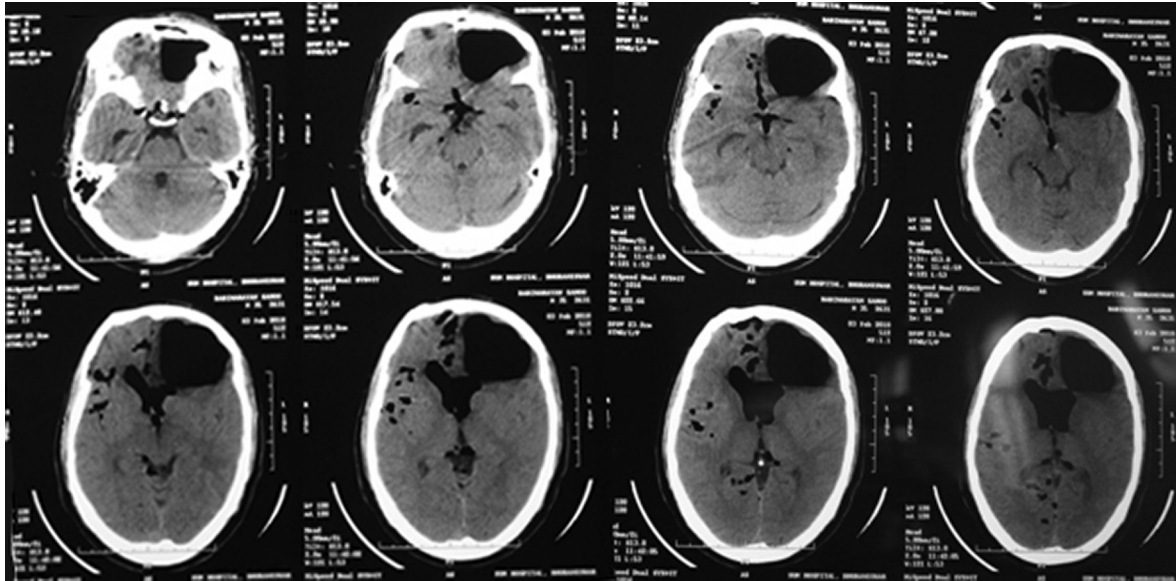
A plain CT head showing a large left frontal intraparenchymal tension pneumatocele causing mass effect with intraventricular and subarachnoid pneumocephalus.
